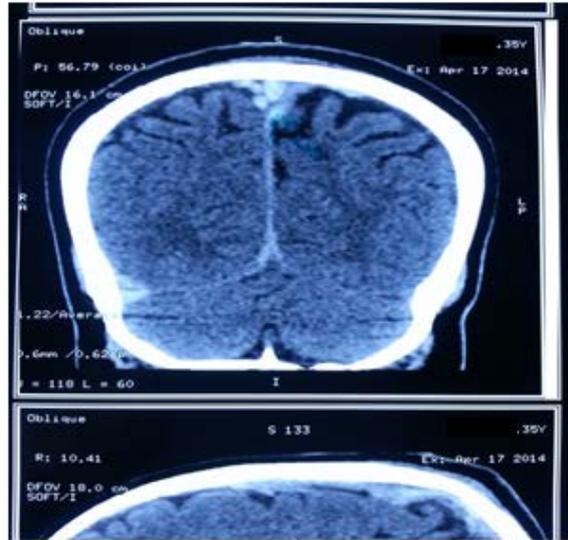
CT scan (axial & coronal section) showing dense triangle sign of the superior sagittal sinus and a hyper density of the straight sinus
